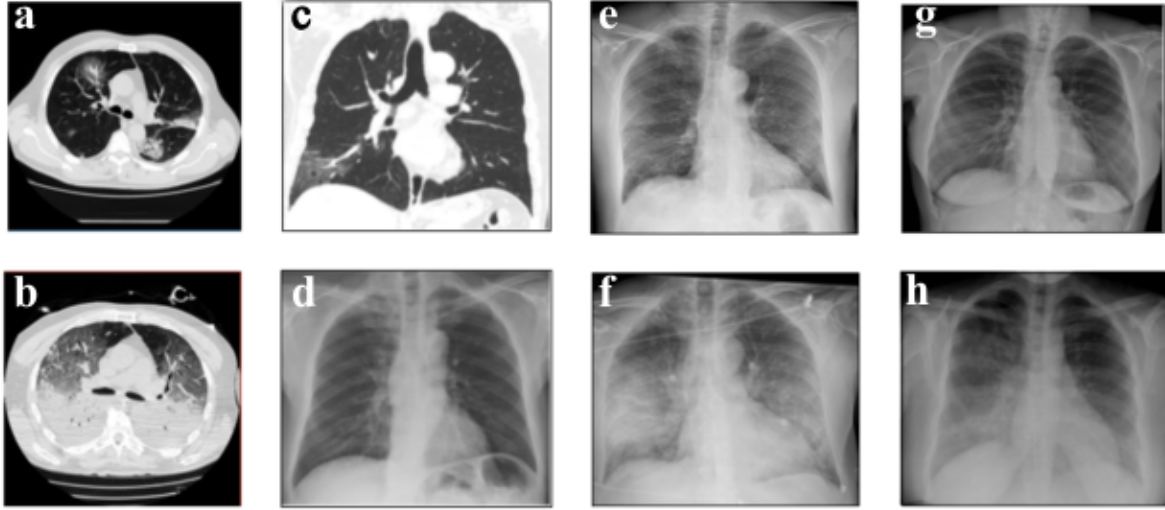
Computed tomography and x-ray data. (a,b) High-resolution CT images of COVID-19 patient at (a) admission to the hospital, (b) 7 days later [11]. (c) Posteroanterior CT and (d) x-ray images of the COVID-19 patient on the same day [16]. X-ray data of a COVID-19 patient at (e) admission, (f) 2 days later. (g) Normal x-ray. (h) x-ray of a patient with viral pneumonia [3].
